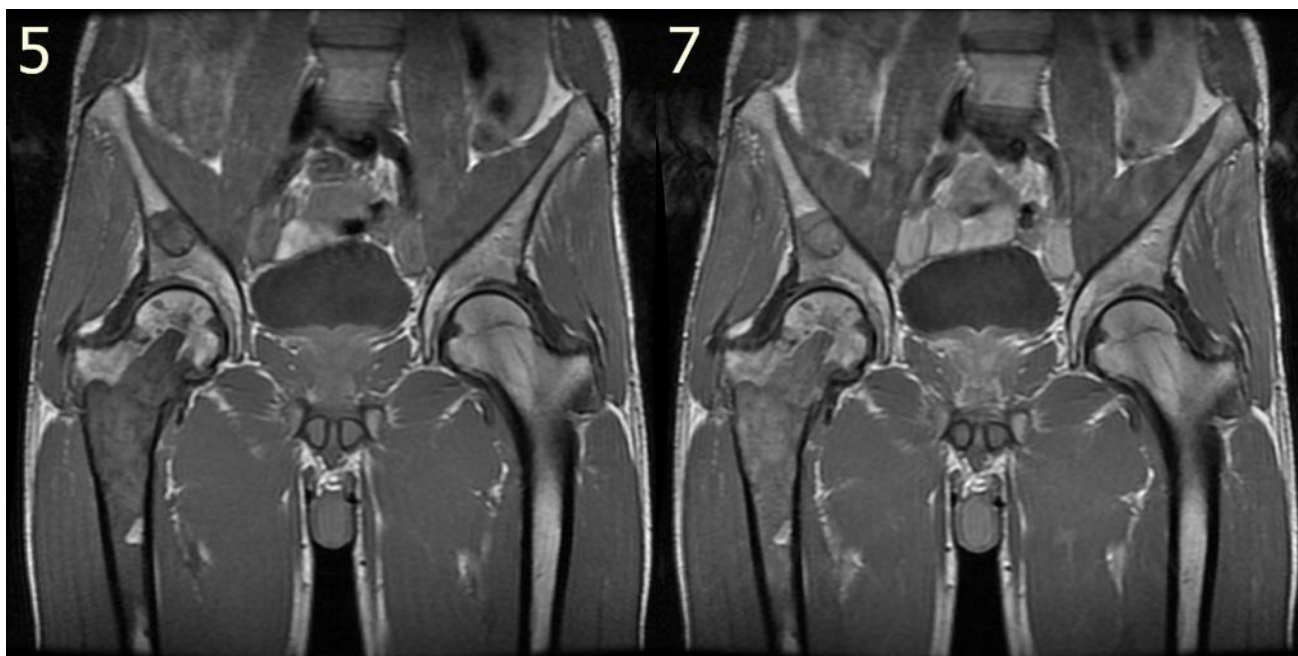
Coronal MRI of the pelvis, T1-weighted image with contrast. The diffuse intraosseous lesions present at the right femur and right ilium show minimal contrast enhancement compared with the aspect of these lesions in Image 5.
